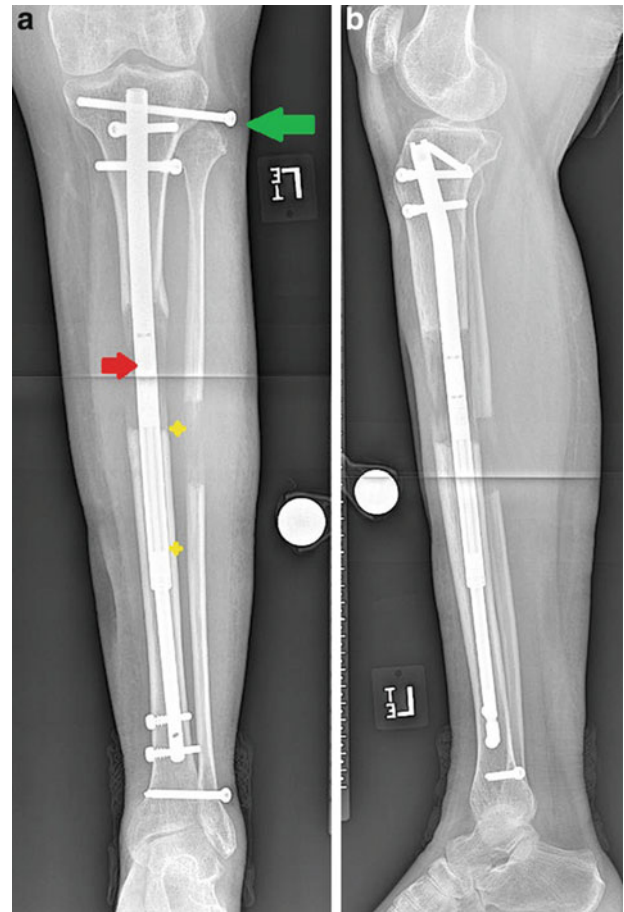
Radiographs 3 months after surgery with excellent bone formation. (a) AP view shows distraction gap of 65 mm. This can be accurately measured on a calibrated radiograph noting the excursion of the rod (distance between the *yellow stars*). Note the proximal fibula has pulled distally despite the screw (*green arrow*). (b) Lateral view showing excellent alignment
